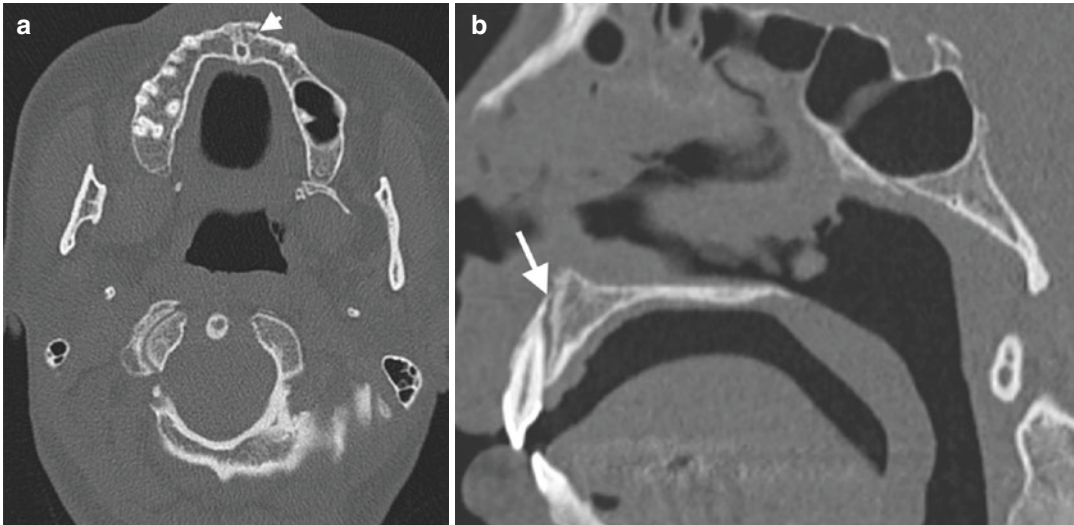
Alveolar process fracture. (a) Axial CT image reveals a fracture (arrowhead) of left first incisor root. (b) Sagittal CT image demonstrates fracture (arrow) oriented in oblique position involving tooth root
